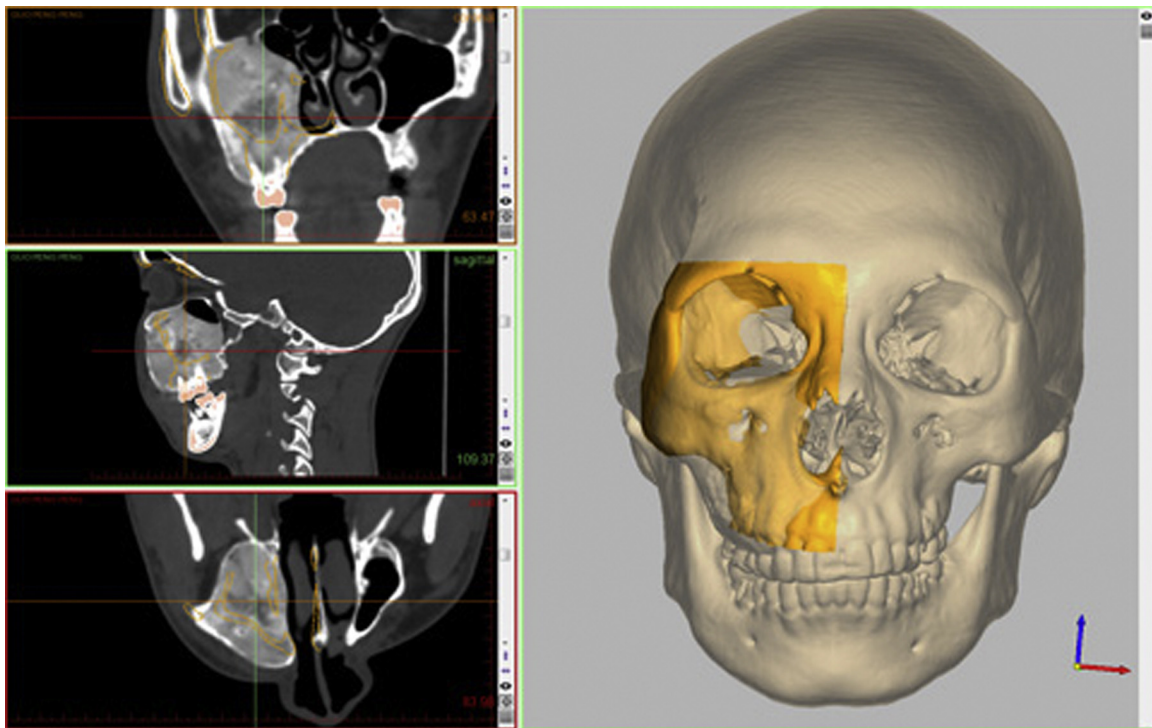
The computed tomographic (CT) data was put into the workstation. The reconstructed CT image gives a sense of the 3-dimensional shape of the lesion that accounts for the clinical appearance. The sagittal plane was chosen as the reference plane and the healthy side was mirrored on to the affected side and better placed manually. The mirrored image was shown in pale yellow while the original image was shown in deep yellow.
